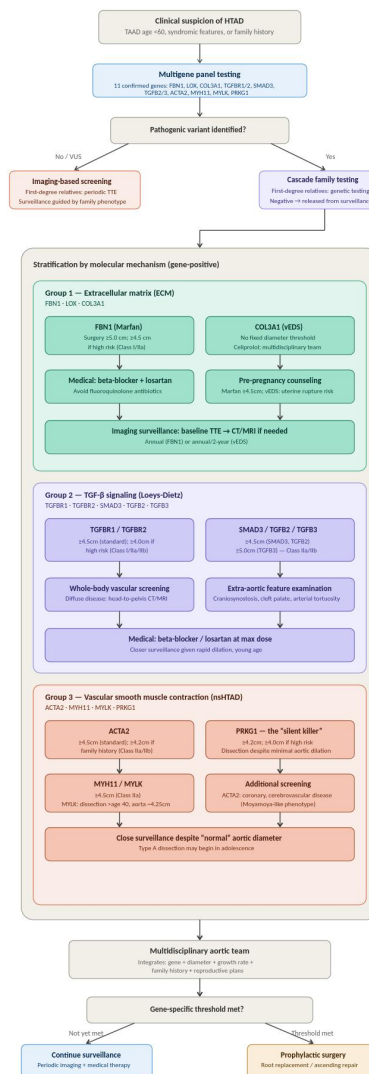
Diagnostic and treatment algorithm for heritable thoracic aortic disease (HTAD): from clinical suspicion to gene-specific individualized intervention. HTAD: heritable thoracic aortic disease; nsHTAD: non-syndromic heritable thoracic aortic disease; TAAD: thoracic aortic aneurysm and dissection; VUS: variant of uncertain significance; TTE: transthoracic echocardiography; CT: computed tomography; MRI: magnetic resonance imaging; ECM: extracellular matrix; TGF- β : transforming growth factor-beta; vEDS: vascular Ehlers-Danlos syndrome; Class I/IIa/IIb: class of recommendation; FBN1: fibrillin-1; LOX: lysyl oxidase; COL3A1: collagen type III alpha 1 chain; TGFBR1/TGFBR2: transforming growth factor-beta receptor type 1/type 2; SMAD3: SMAD family member 3; TGFB2/TGFB3: transforming growth factor-beta 2/beta 3; ACTA2: actin alpha 2, smooth muscle; MYH11: myosin heavy chain 11; MYLK: myosin light chain kinase; PRKG1: protein kinase cGMP-dependent type 1.
